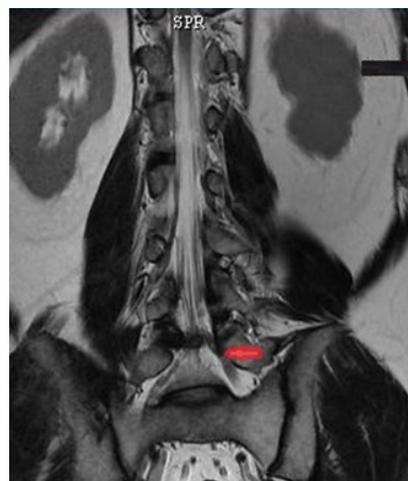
Coronal T2-weighted MRI demonstrated the traction generated on the contralateral nerve root.
